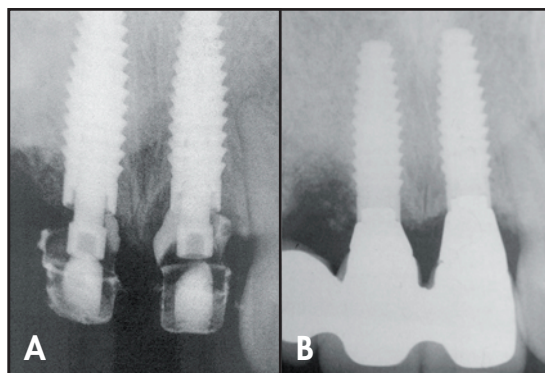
Radiographic appearance of the implants immediately following placement. 18B. Postoperative appearance 2.5 years following implant loading.
